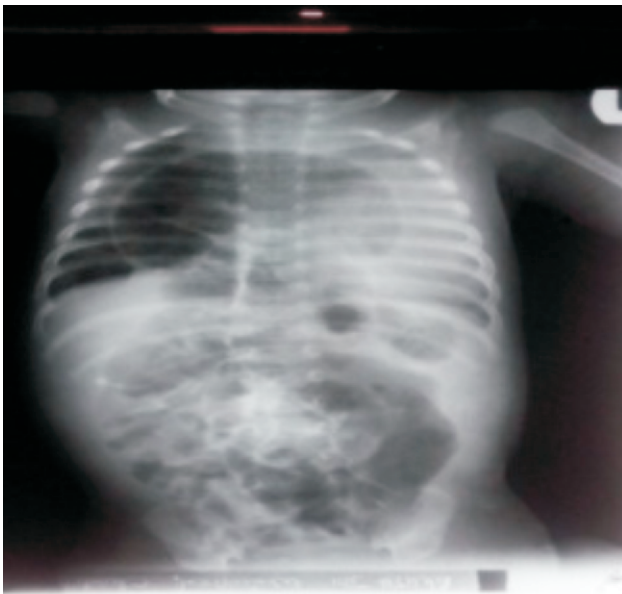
chest radiograph, showing well circumscribed loop of bowel occupying the mediastinum
